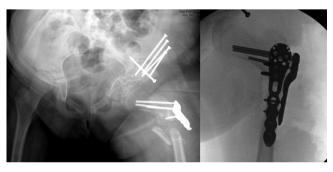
Three week post-operative radiograph showing periprosthetic femur fracture (left). Intra-operative fluoroscopic view of anterior plating of the periprosthetic fracture (right).
